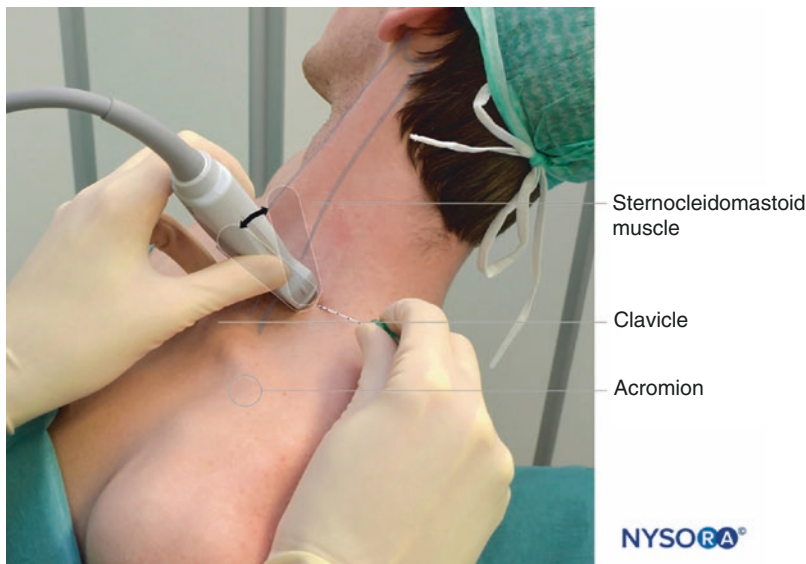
Ultrasound-guided interscalene brachial plexus block: transducer and needle position to obtain the desired ultrasound image for an in-plane approach. The knowledge of external landmarks substantially facilitates and shortens the time to obtain the view necessary for block performance. The transducer is positioned behind
